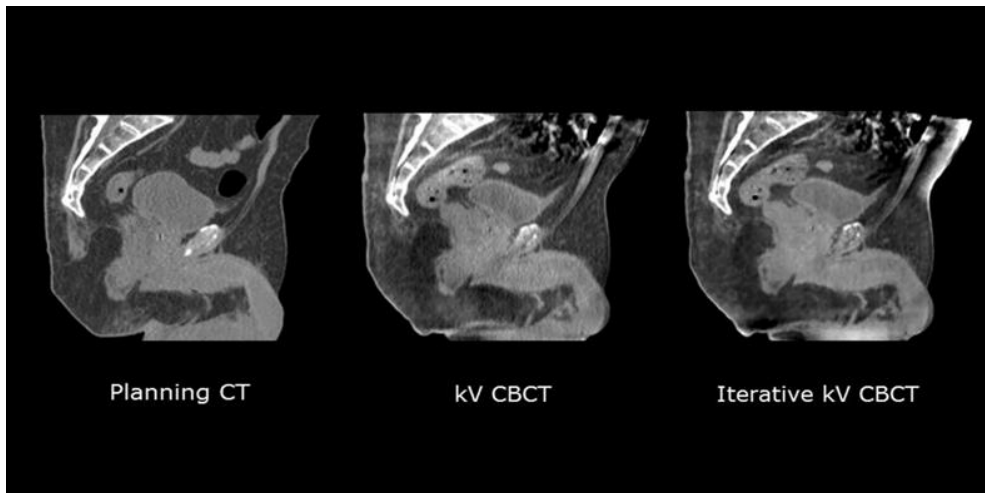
Sagittal images of pelvis area (CT, kV CBCT and iCBCT)
